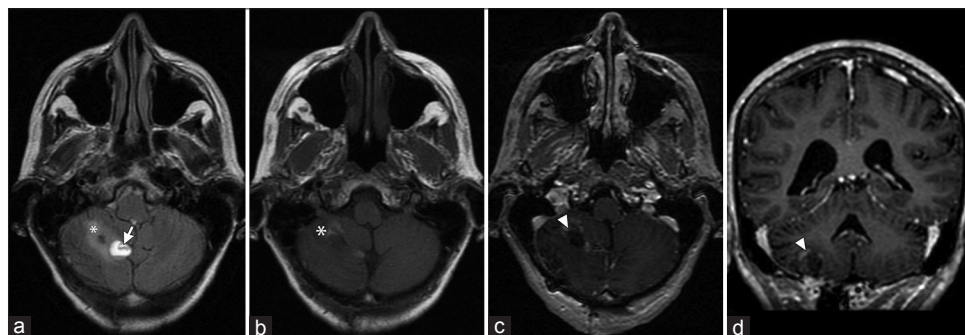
Postoperative brain MRI sequences (13 days later). (a) T2-weighted FLAIR axial; (b) T1-weighted axial without contrast; (c) T1-weighted axial with contrast; (d) T1-weighted coronal with contrast. Images show a small hematoma (arrow) in the medial aspect of the surgical cavity, mild residual edema (asterisk) and minimal linear postsurgical enhancement (arrowhead) without evidence of a residual lesion
